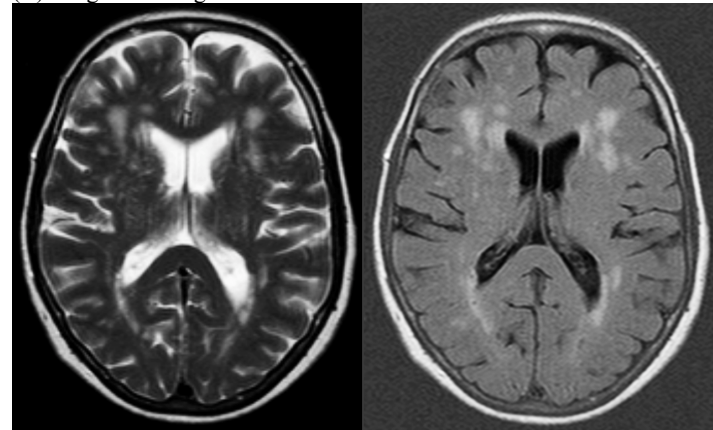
WMLs identified at co-registered T2w TSE (A) and FLAIR (B) images showing WMLs.
